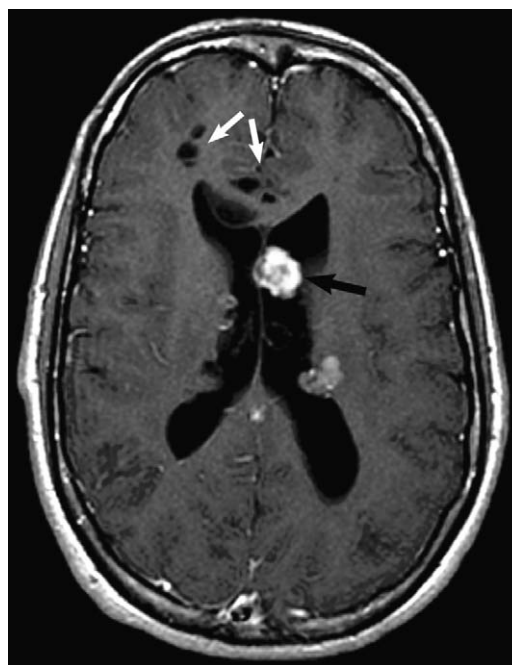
Tuberous sclerosis. Axial T1-weighted postcontrast image demonstrates multiple enhancing and non-enhancing subependymal tubers. The large enhancing lesion in the vicinity of the foramen of Monro (black arrow) is consistent with a giant cell tumor. Mild enlargement of the left lateral ventricle may be related to intermittent obstruction of the foramen of Monro. Note multiple periventricular parenchymal cysts (white arrows), not uncommonly identified in tuberous sclerosis.
